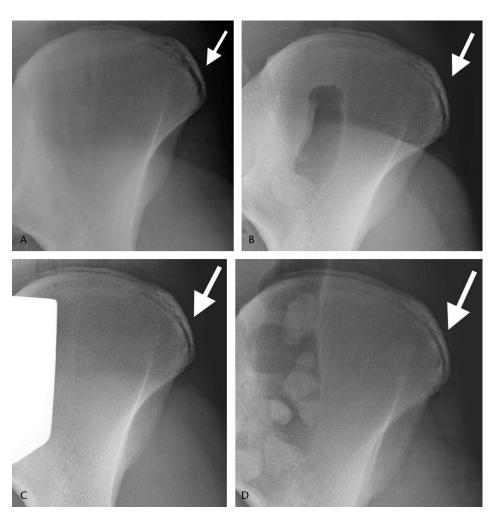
Anteroposterior pelvis radiographs at baseline (A) and at 7 months (B), 9 months (C), and 10 months (D).
